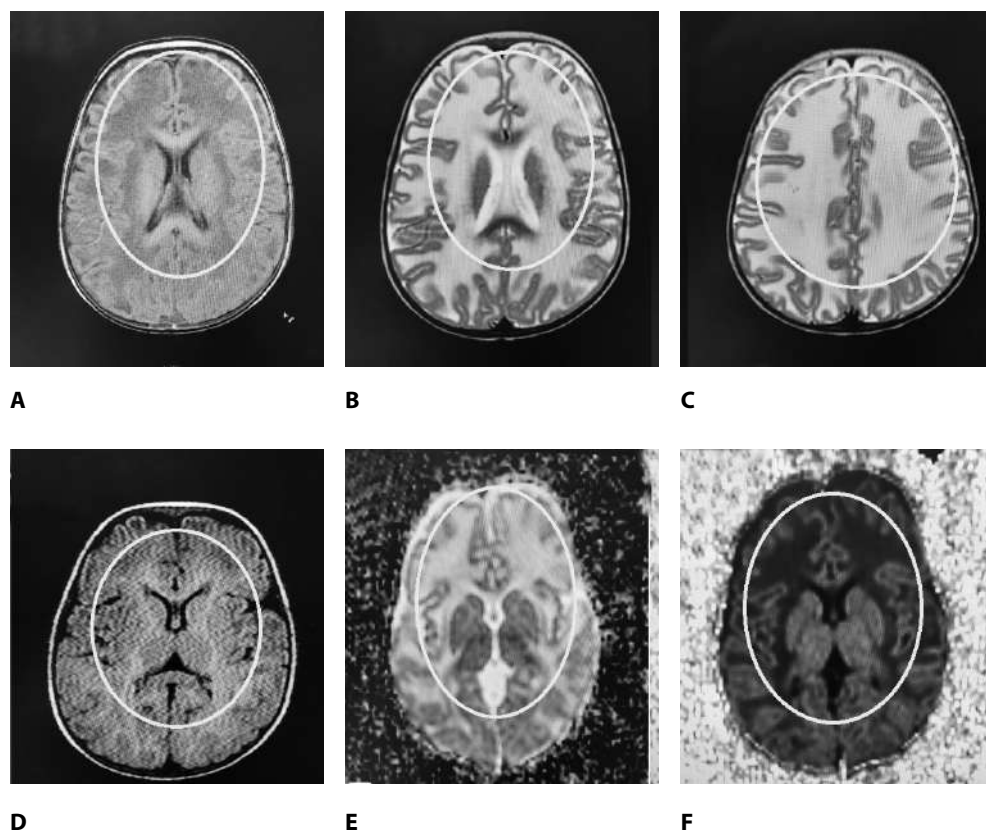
20 months girl (Canavan disease: a neurological disorder in which the brain degenerates into spongy tissue full of small fluid-filled spaces): A. T1 axial: bilateral diffuse periventricular hypointensities. B. T2WI axial and C. FLAIR show: bilateral diffuse periventricular and subcortical, fibers hyperintense lesion. D. DWI: no diffusion restriction. F. ADC map: no restriction diffusion
